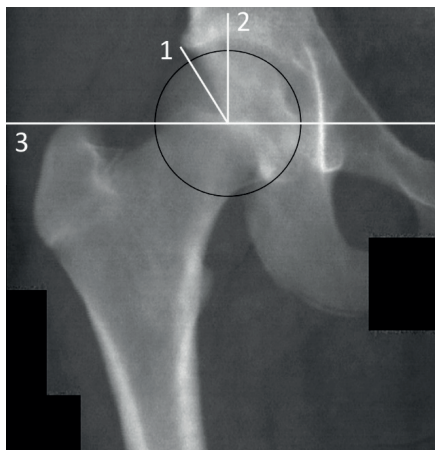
The lateral centre edge angle (LCEA) as determined on a right hip dual-energy x-ray absorptiometry (DXA) image. The LCEA is defined as the angle between line 1 connecting the most lateral bony point of the acetabulum with the femoral head centre and line 2 through the femoral head centre perpendicular to the horizontal reference line of the pelvis (line 3).
